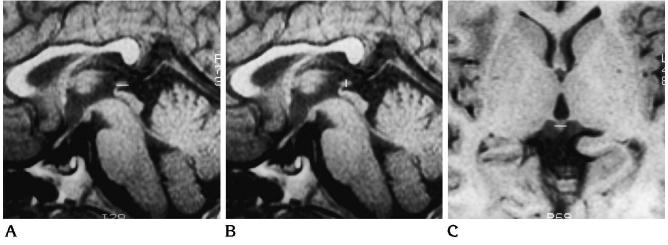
MR images of the pineal gland in a 4-year-old girl with myelomeningocele (volume 37.5 mm<sup>3</sup>). *A*, The length of the pineal gland (*white line*) is 5 mm on T1-weighted sagittal image.
